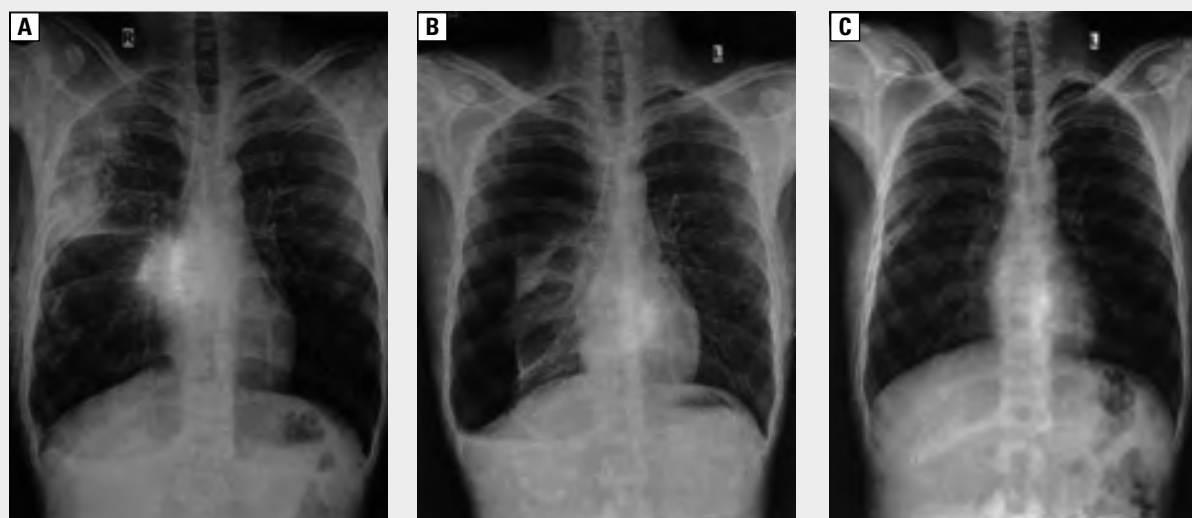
A. On presentation, chest radiograph showing dense, nonhomogenous air-spaced opacity over the right upper zone, horizontal fissure prominence, emphysematous changes with a chest tube *in situ*; B. Previous hospital chest radiograph showing large right pneumothorax with minimal fluid, collapsed lung noted medially in the right mid and lower zone; C. Repeat chest radiograph showing complete resolution of the radiographic abnormality.
